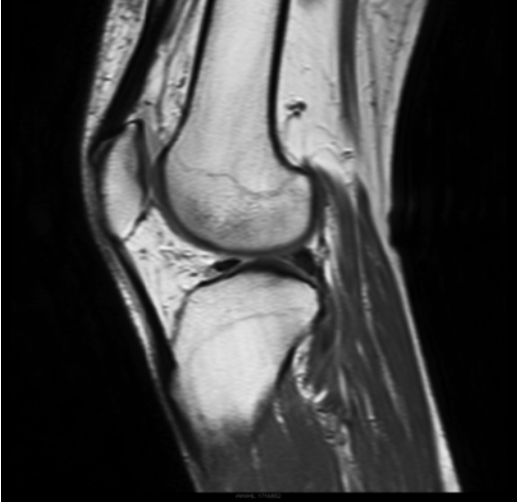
Sagittal magnetic resonance image of the patient
